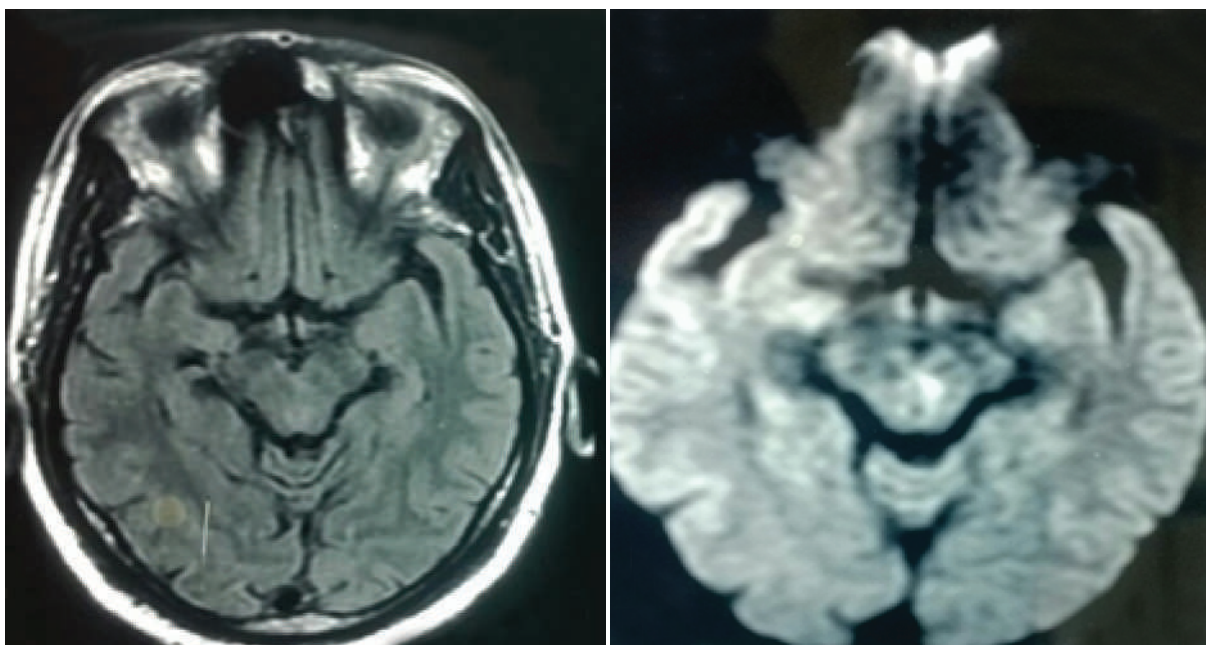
MRI showing small acute infarct in left dorsal para median midbrain.
